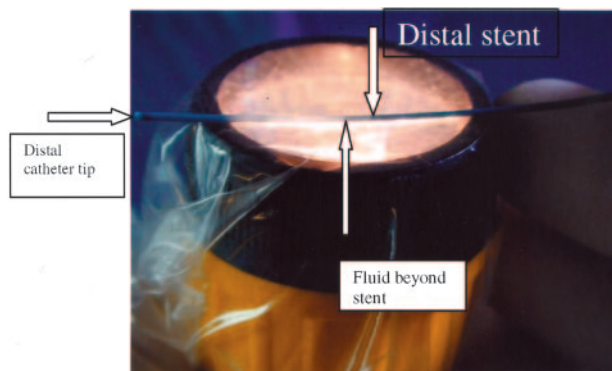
Distal tip of Mass TRANSIT catheter over flashlight in sterile sonography sleeve. Arrow, distal stent. Opacity beyond the stent is fluid within the catheter.
